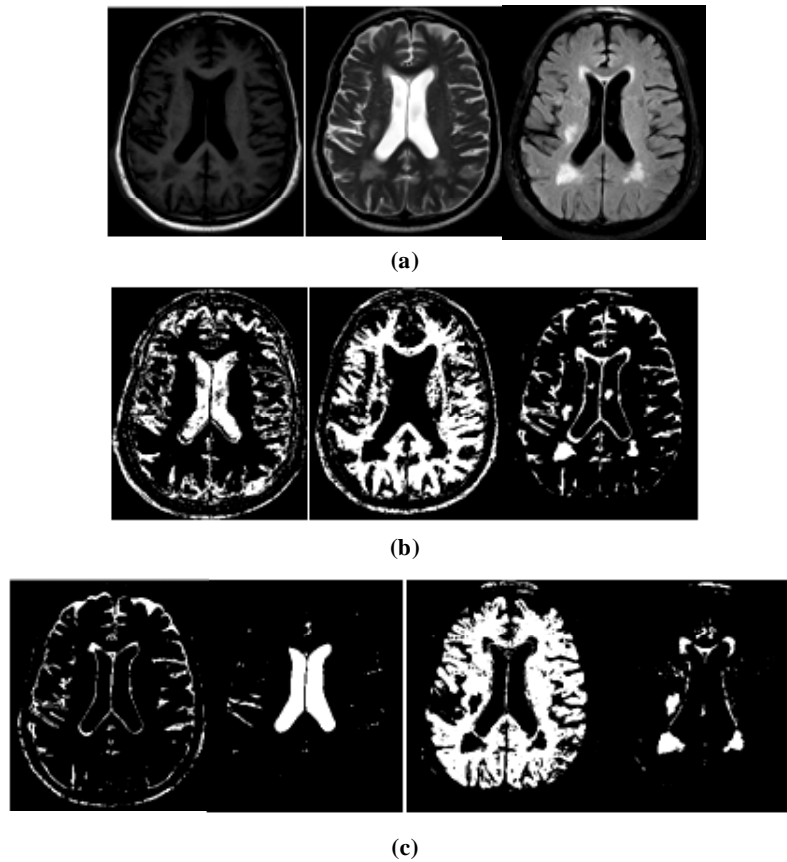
Results obtained with clinical MRI brain image (a) T1,T2, FLAIR images. (b) Classified images using FGGM-EM(without ICA) (c) Classified images of the ICs using FGGM-EM.
